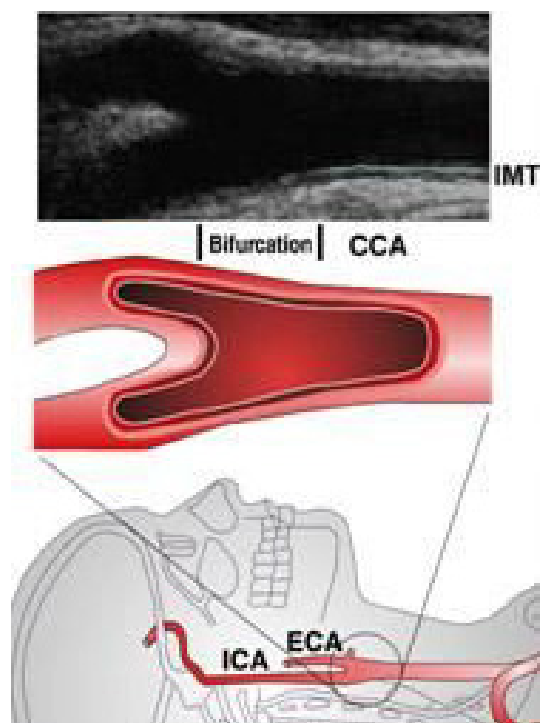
From top to bottom: Demonstration of B-mode ultrasound CCA image; CCA anatomy shape; CCA anatomy position.
